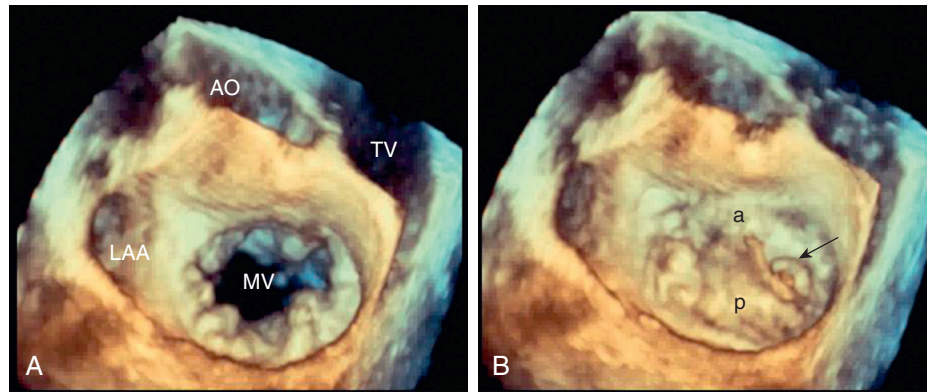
■ Three-dimensional (3D) echocardiography of the same patient as in Fig. 85-2 in both diastole (A) and systole (B). 3D imaging provided a “surgeon’s view,” allowing instant viewing of the mitral valve en-face to assist operative planning for potential repair. In systole, the posterior leaflet (p) can be seen to prolapse above the anterior (a) leaflet, and ruptured chordae with flail segments can be seen (white arrow). AO, aorta; LAA, left atrial appendage; MV, mitral valve; TV, tricuspid valve.
